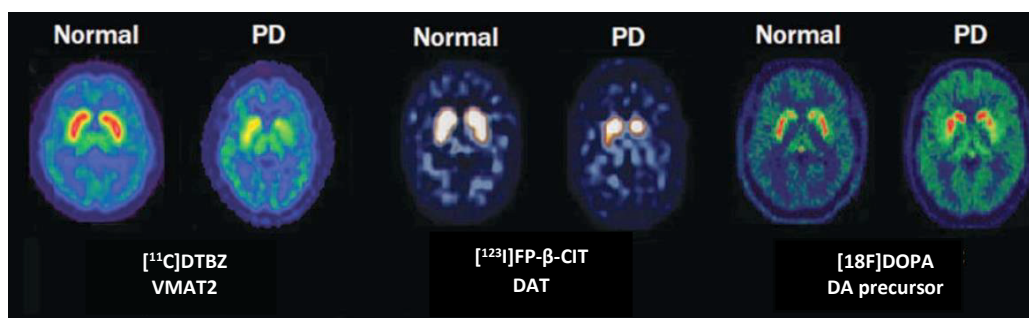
Molecular imaging of dopaminergic dysfunction in PD. Example of PET ($[^{11}\text{C}]\text{DTBZ}$ and $[^{18}\text{F}]\text{DOPA}$) and SPECT ($[^{123}\text{I}]\text{FP-}\beta\text{-CIT}$) imaging in a PD patient that show decreased VMAT2 activity, DAT availability and synthesis of DA (low uptake in all cases resultant from neuronal loss) compared with a healthy control. Adapted from [77].
